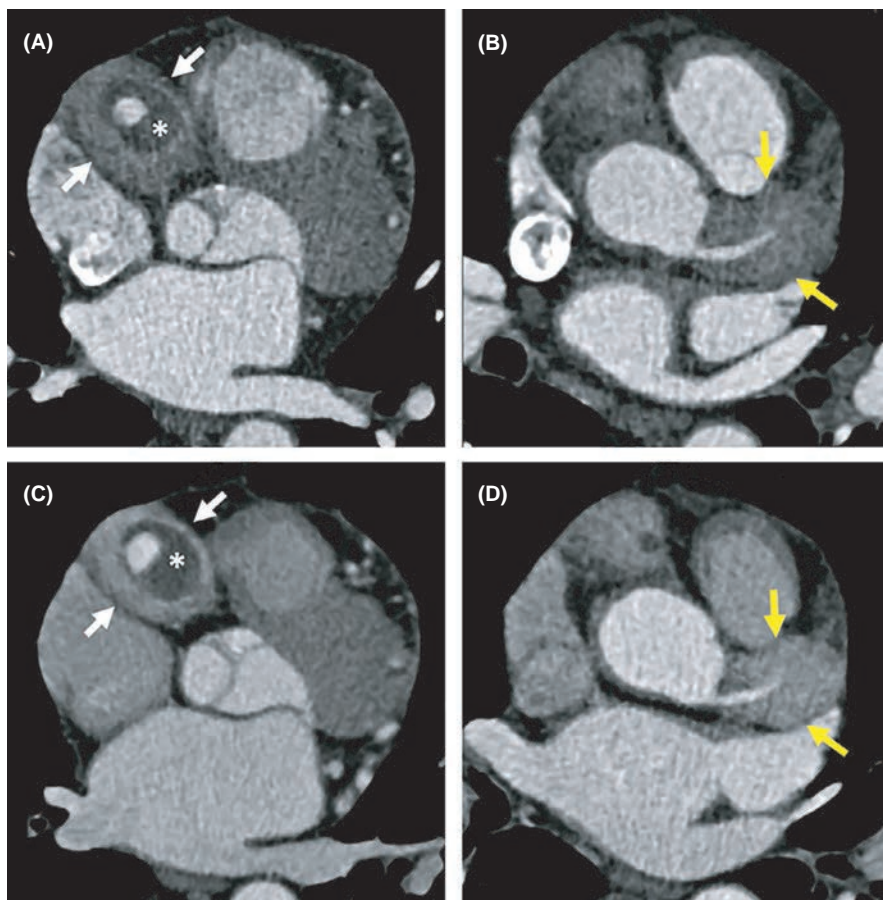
Axial coronary computed tomography angiography (CTA) image shows wall thickening and a partially thrombosed (A, asterisk) aneurysm in the right coronary artery (RCA) (A, white arrows). Also, marked wall thickening is observed in the left anterior descending artery (LAD) (B, yellow arrows). In follow-up axial coronary CTA, although the total size of the RCA aneurysm is stable, there was a slight increase in patent lumen size (C, white arrows). Partial thrombus is still observed in the aneurysm (C, asterisk). The wall thickness of LAD is stable (D, yellow arrows). Note that there is wall enhancement in RCA aneurysm (C) and LAD (D)
